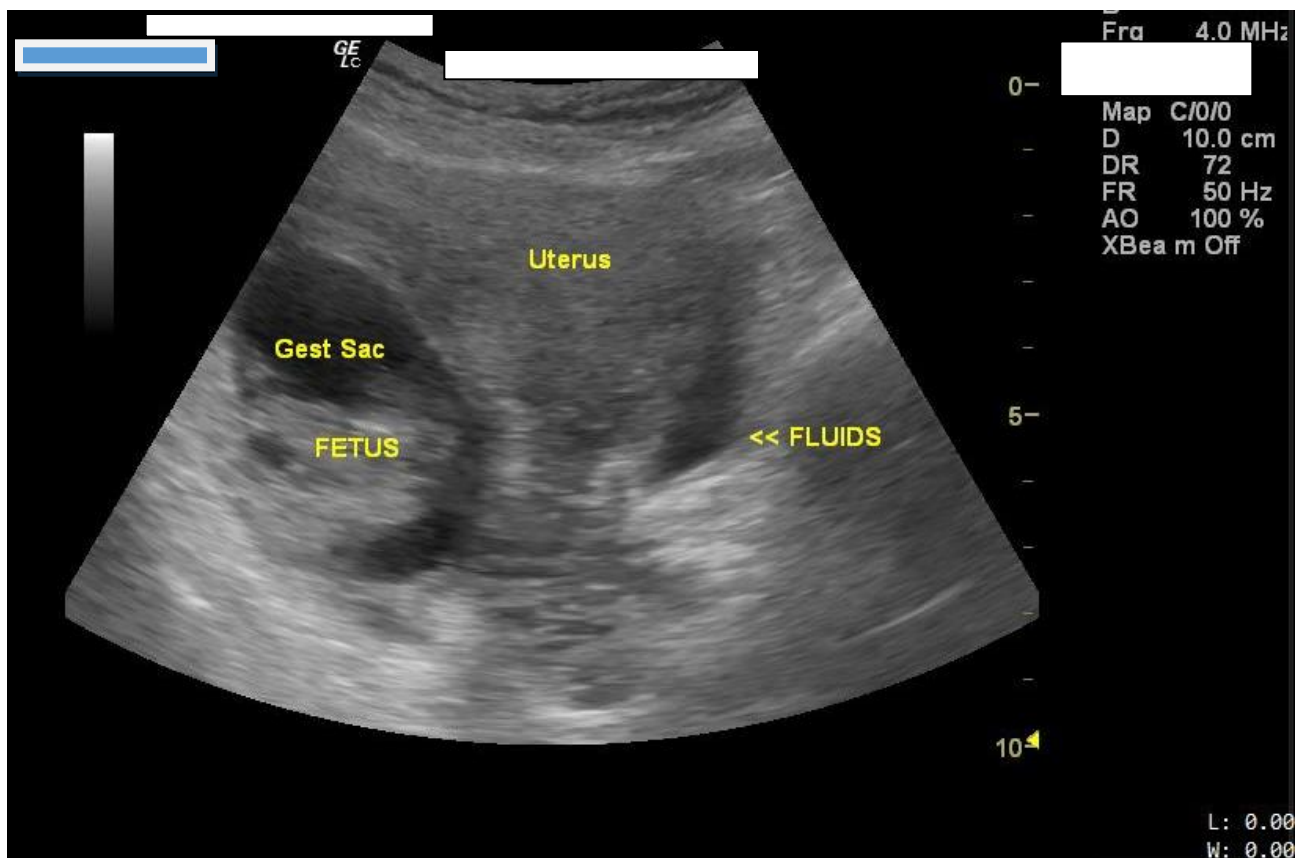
Pelvic ultrasound shows a bulky and empty uterine cavity with right adnexial mass and fluid in the pelvis
